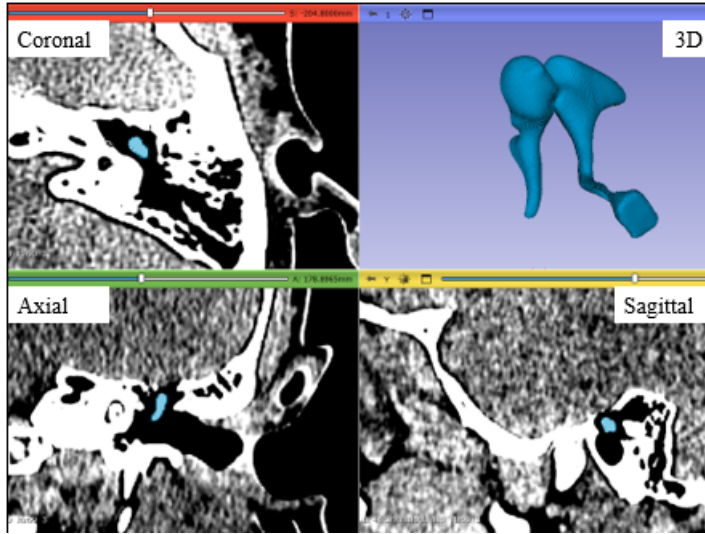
Radiological image of the human middle ear obtained by computed tomography.
